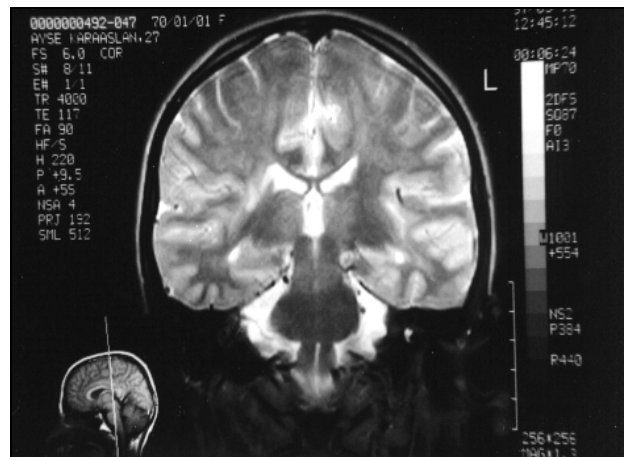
Large focal area as of increased signal intensity at T2 weighted image MRI in the left temporal lobe.
